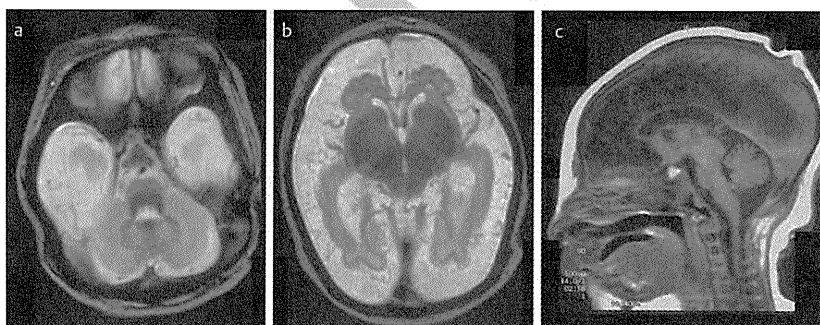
Brain MRI of older sister at age of day 0. The MRI (a and b: T₂-weighted image [TR 4000, TE 132], c: T₁-weighted image [TR 500, TE 14.0]) showing hypoplasia of bilateral cerebral hemispheres with enlarged extraaxial space, a simplified gyral pattern without a thickened cortex, hypoplastic corpus callosum, and a mildly flattened brain stem.
